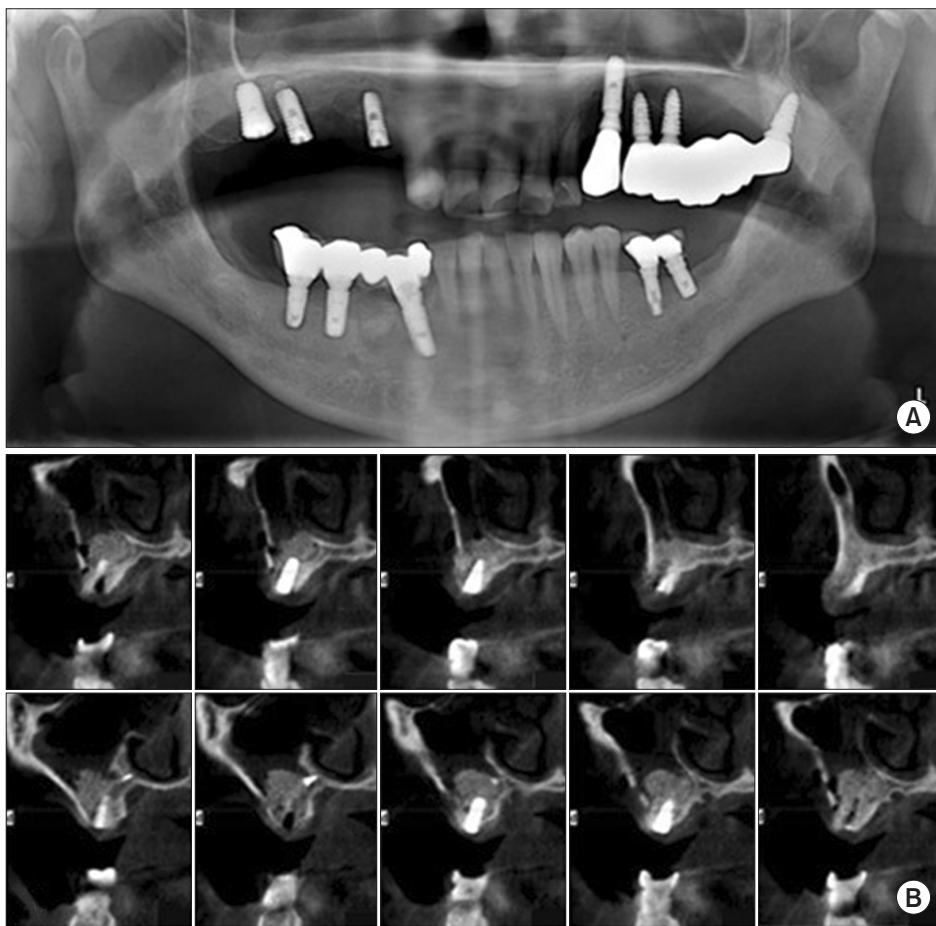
Postoperative radiographs showing that the resorbable barrier membrane, which was internally fixed and stabilized by a titanium screw, maintained its proper position and prevented the loss of graft material into the sinus cavity. Panoramic radiograph (A) and cone-beam computed tomography (B) images showing the titanium fixation screw at the medial bony wall of the sinus.
